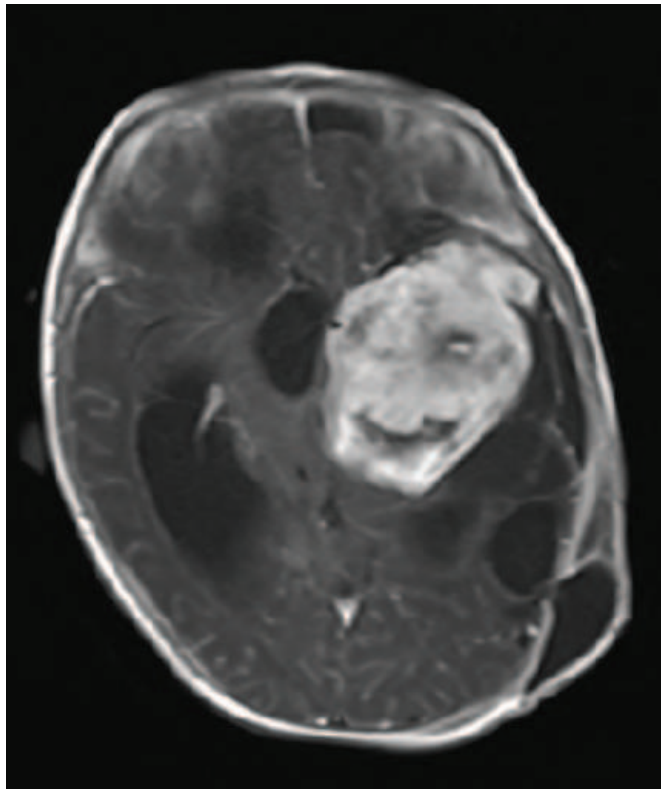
Initial brain MRI. Axial contrast-enhanced T1-weight imaging showed a large area of signal abnormality with an inhomogeneous space-occupying lesion which replaced the left temporal lobe.
